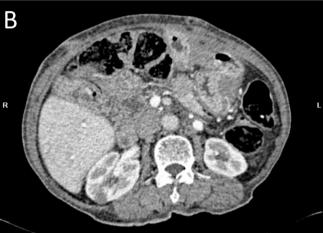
Postoperative CT: (A) a patent superior mesenteric artery / superior mesenteric vein with no obvious thrombosis; (B) along its branches with pneumatosis intestinalis.
